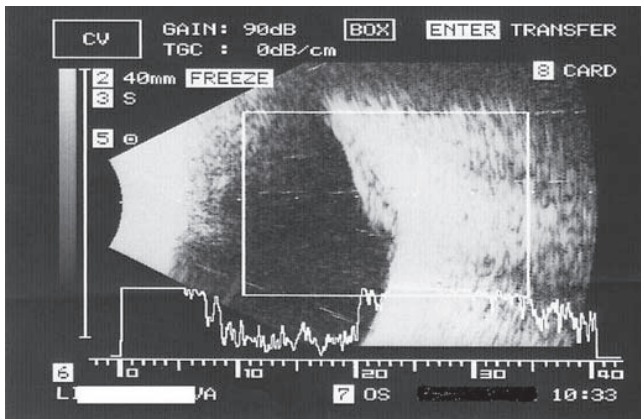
Ultrasound image of deposit (December 2011)
